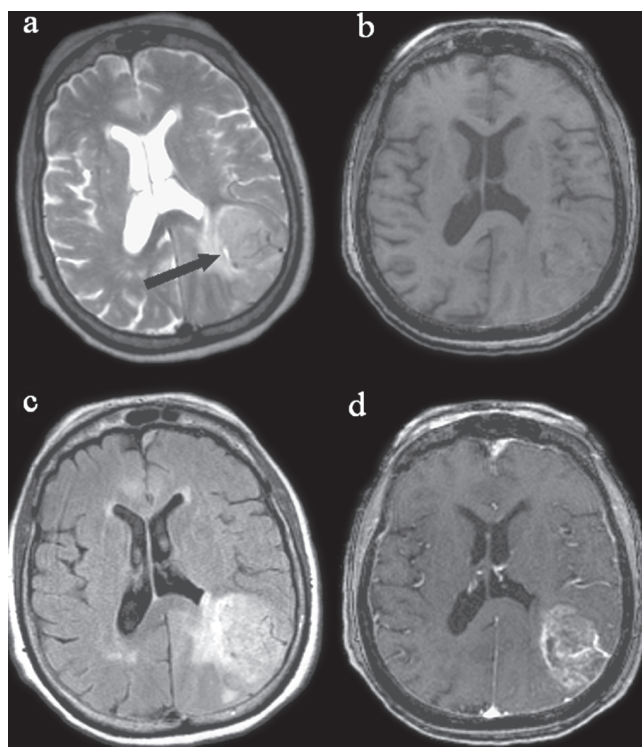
High-grade glioma. Axial T2-weighted image (a) demonstrates an ill-defined, hyperintense (compared to gray matter), heterogeneous mass in the left parietal lobe along with vasogenic edema along the white matter tracts. Note the presence of necrotic foci (arrow) within the tumor. This mass appears as iso to hypointense on T1-weighted image (b) and hyperintense on FLAIR image (c). There is a heterogeneous contrast enhancement within the mass on the corresponding post contrast T1-weighted image (d)
